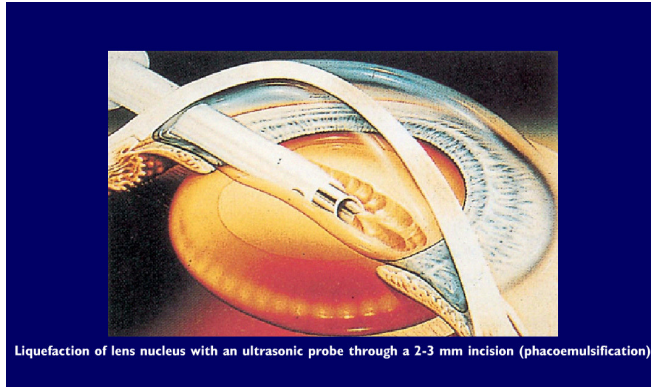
Liquefaction of nucleus with an ultrasonic probe (phacoemulsification). (Khaw 2004)
